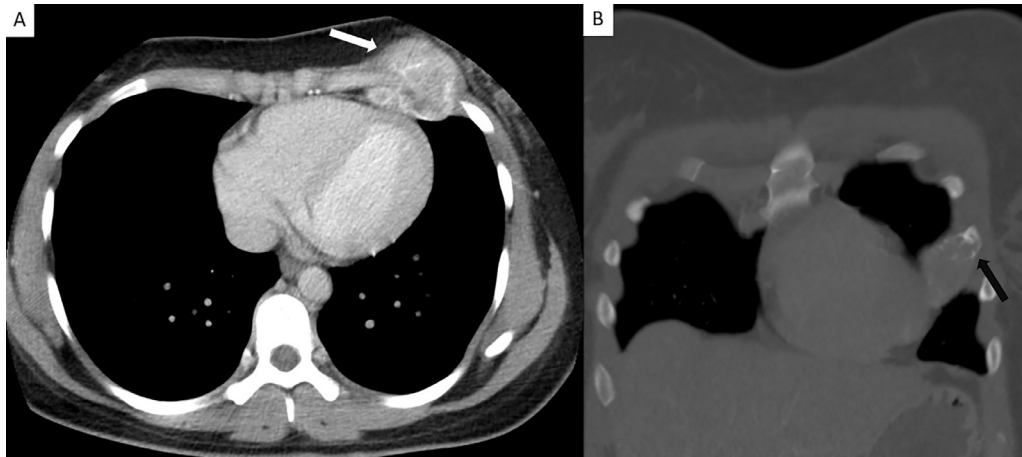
Axial contrast-enhanced chest CT (A) demonstrates a heterogeneously enhancing anterior chest wall mass (white arrow) with local invasion of the chest wall musculature and pleura, as well as proximity to the left ventricular apex concerning for pericardial invasion. Coronal bone window CT image clearly shows the mass arising from the anterior fifth rib (black arrow).
